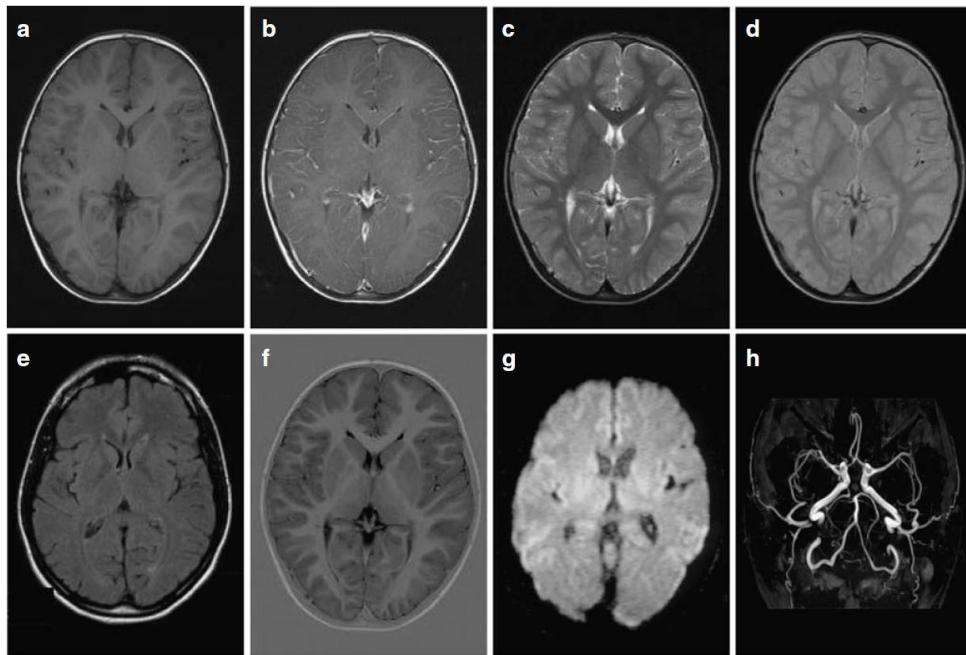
Choice of multi-parameter soft tissue contrasts available with MRI. Repeated MRI imaging of an axial cross-section through the brain of a normal volunteer demonstrates how the soft tissue contrast can be varied simply through the appropriate choice of imaging sequences and corresponding sequence parameters. (a-d) show the basic MRI contrasts: (a) T1-weighting (T1w), (b) T1w with contrast agent, (c) T2w, (d) proton-density-weighted. (e) and (f) show FLAIR and inversion recovery sequences, respectively. (g) Diffusion-weighted image of the brain, and (h) provides a maximum-intensity projection (MIP) of a non-contrast-enhanced 3D time-of-flight (TOF) angiogram of the intracranial vessels. Reproduced from [209] with permission from the authors.
